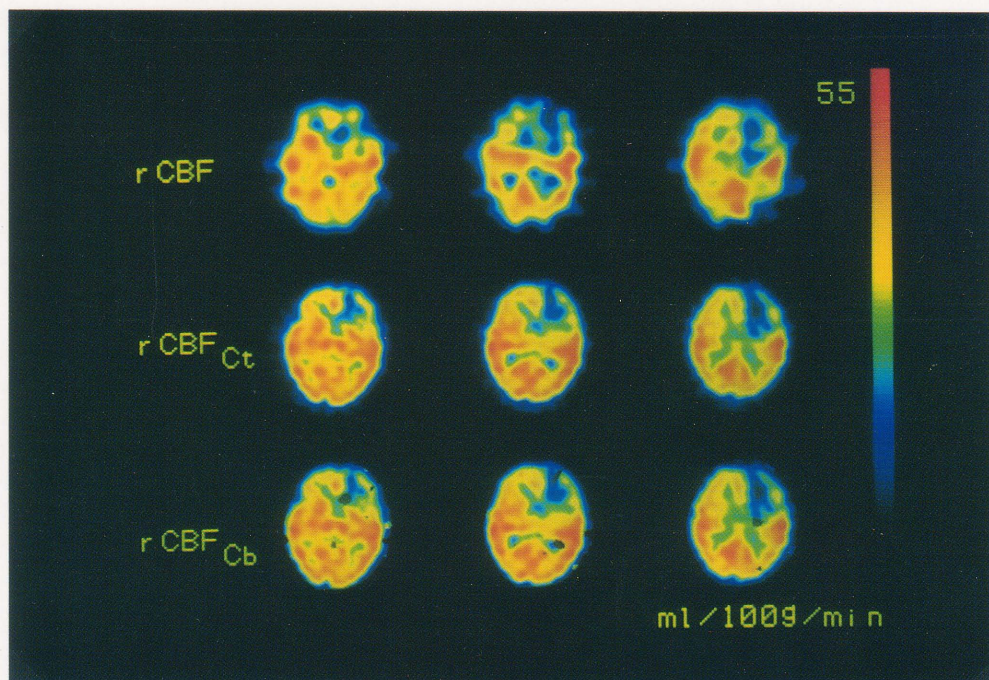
Regional CBF images for each procedure. A 61 year-old female with cerebral hemorrhage. rCBF: rCBF images obtained from short time SPECT at 5 min. rCBF_{Ct}: rCBF images obtained from static SPECT corrected by total brain counts. rCBF_{Cb}: rCBF images obtained from static SPECT corrected by each reconstructed counts for ROI. The numbers show rCBF value (ml/100 g/min).
